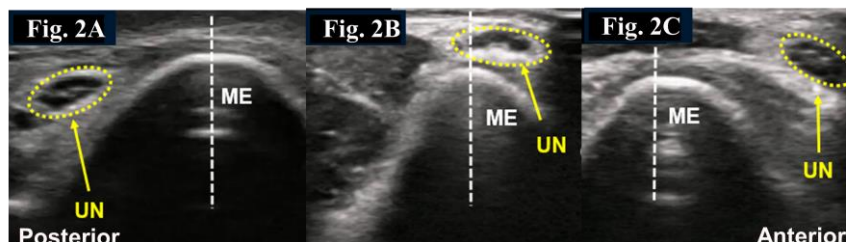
Classification of ulnar nerve mobility with ultrasound
